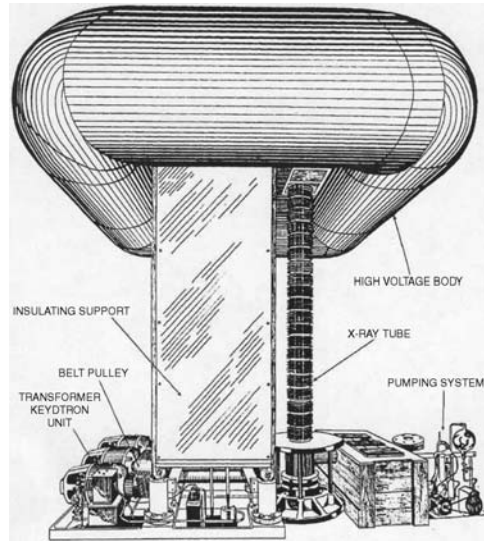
The Trump–Van de Graaff X-ray generator installed at the Harvard Medical School (Reprinted from [1]; copyright 1937, with permission from APS)
